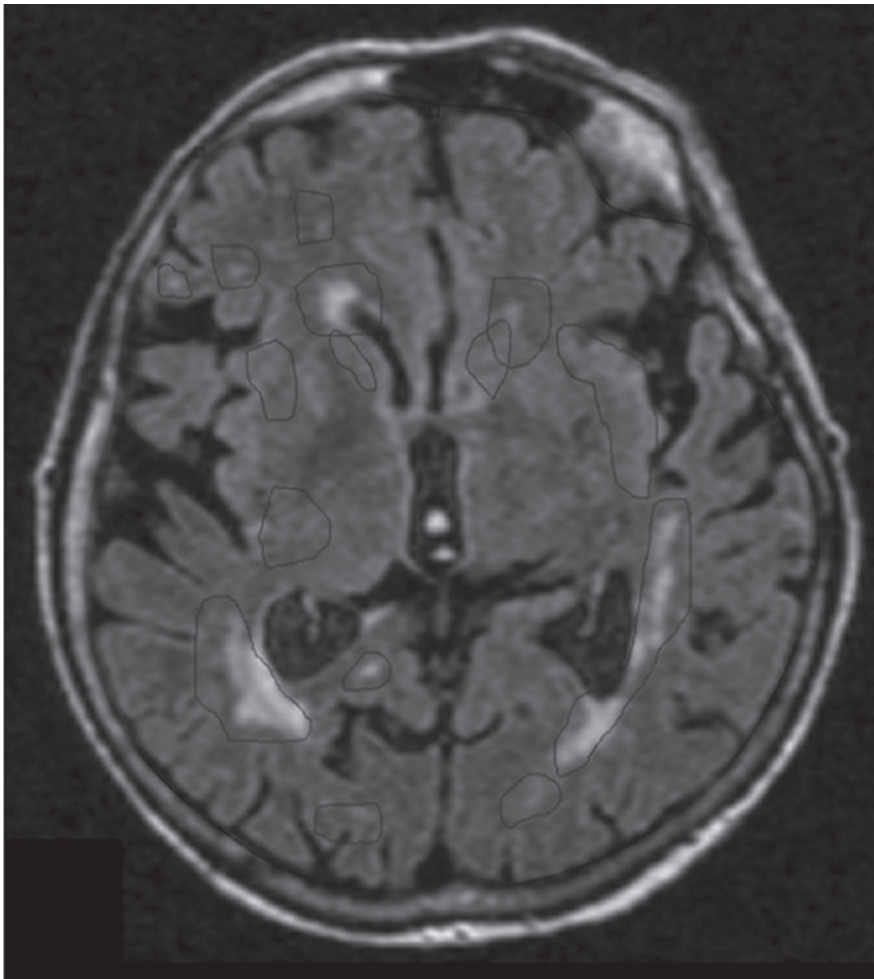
Volumetric procedure – 1.5 T MRI transverse brain section in FLAIR sequence. The marked areas include not only pathological foci, but neighbouring brain tissue. After postprocessing, with the application of filters the average white matter signal is balanced to the caudate nucleus. However, the only hyperintense lesions that remain are the pathological foci.
